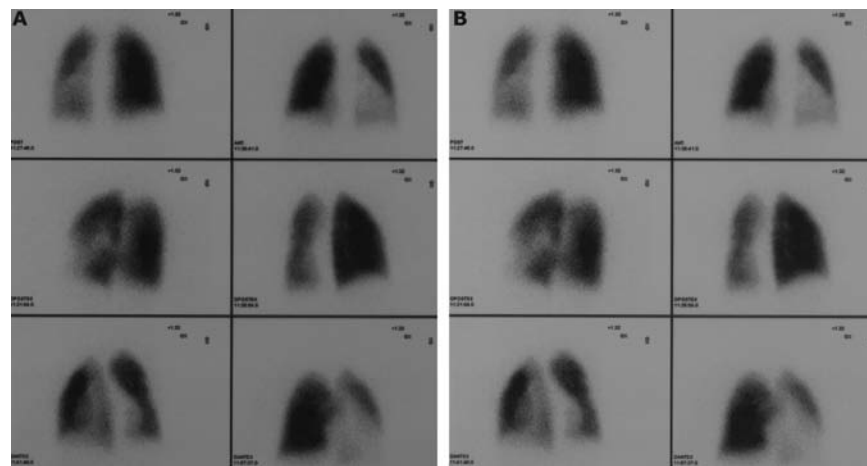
Pulmonary perfusion scintigraphy before (A) and 1 year after BMT (B)
